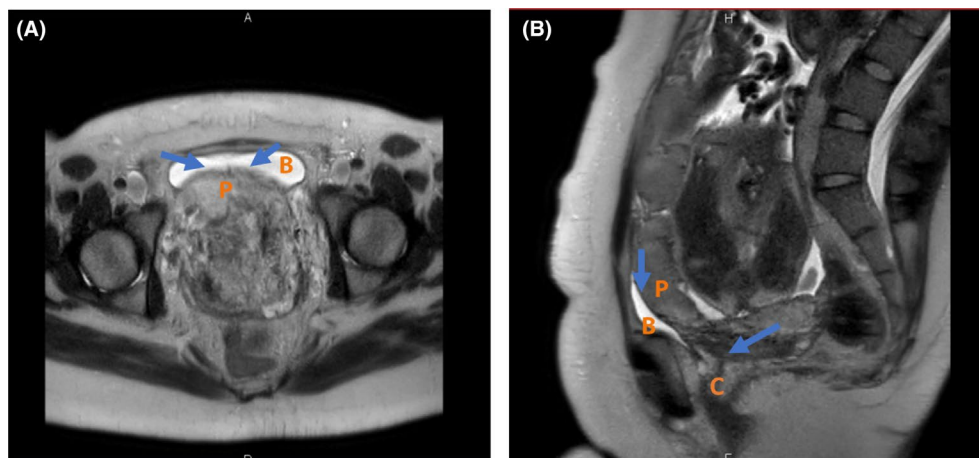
T2 weighted MRI at 28 weeks of pregnancy showing a placenta anterior and previa. No myometrium can be identified under the placenta in the lower segment of the uterus. (A) Coronal view and (B) sagittal view (showing a placenta previa covering the internal cervical os).
